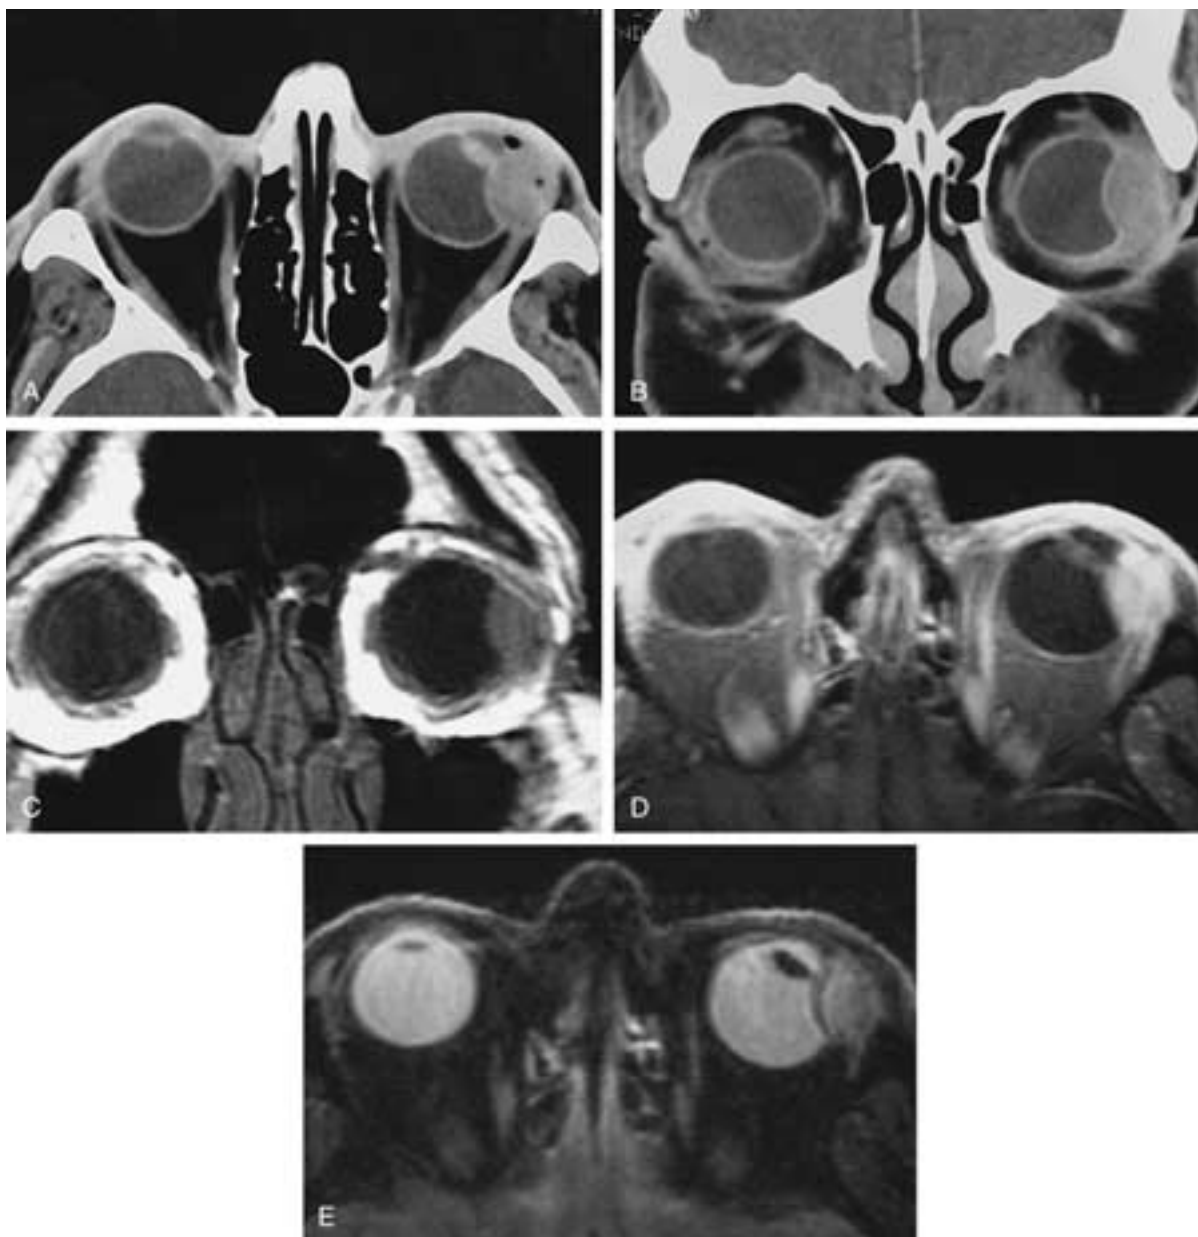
Malignant fibrous histiocytoma. Axial (A) and coronal (B) contrast-enhanced CT. The contrast-enhanced CT studies on this 58-year-old man demonstrate a well-defined, moderately enhancing mass at the left lateral globe margin, which indents the globe without visibly invading the dense sclera. A small amount of gas is present in the mass after needle biopsy. C, Coronal T1-weighted image (TR/TE = 600/12) reveals that the mass is intermediate in signal intensity. D, Axial, fat-saturation, T1-weighted image (600/12) shows moderate gadolinium enhancement. E, Axial, conventional, STIR (TR/TE/T1 = 2000/43/170) image shows that the mass is hyperintense to temporalis muscle, slightly hypointense to the vitreous, and separated from the globe contents by the hypointense band of sclera. At surgery, it arose from the ciliary body near the tendinous insertion of the lateral rectus muscle. (From Dalley RW. Fibrous histiocytoma and fibrous tissue tumors of the orbit. *Radiol Clin North Am* 1999;37:185–194.)
